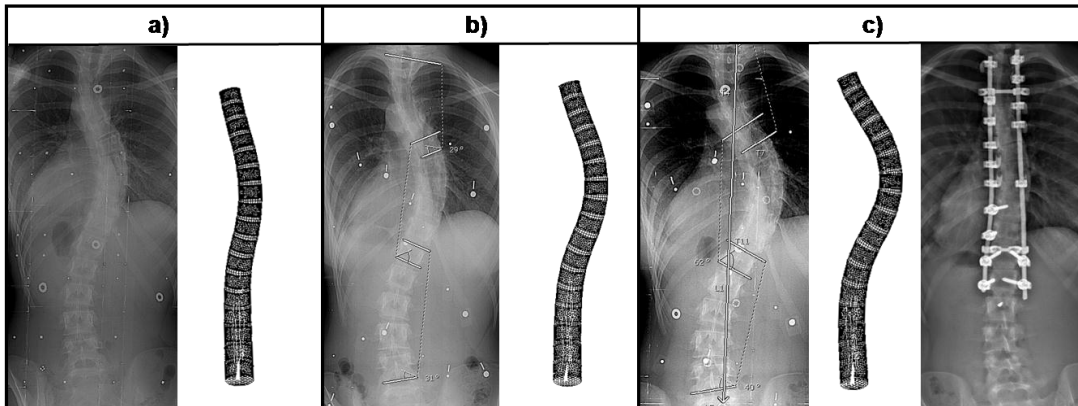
Article 2 figure 5 Patient radiographs and non-instrumented scoliotic model at a) 13 years b) 14 years and c) 15 years & post-operative radiograph following posterior fusion
